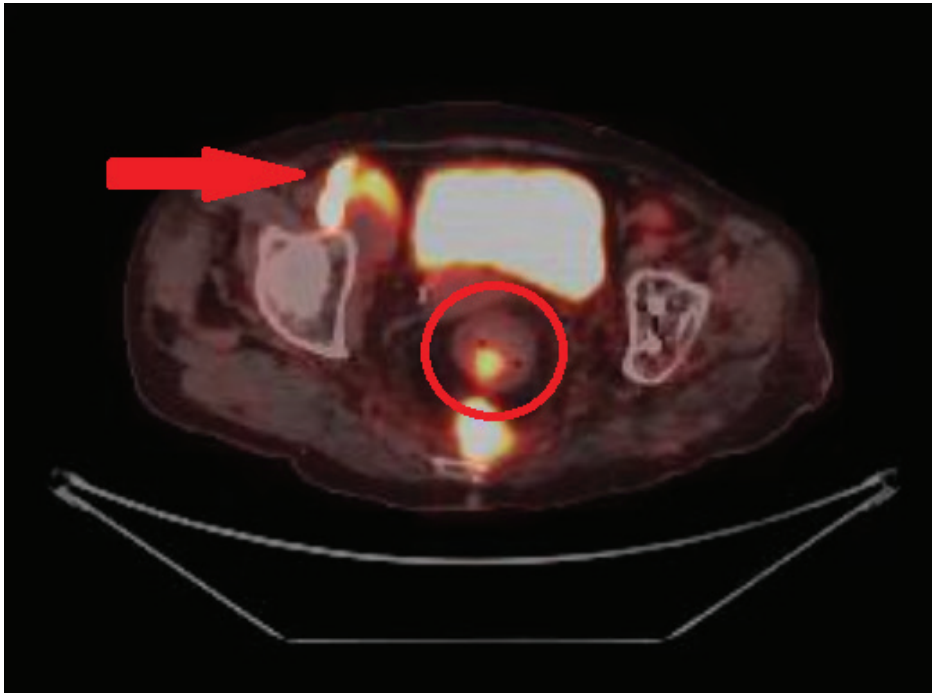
PET-CT image: A mass extending from the right iliac region to the obturator fossa (indicated with an arrow) and thickened rectal wall (circled)
